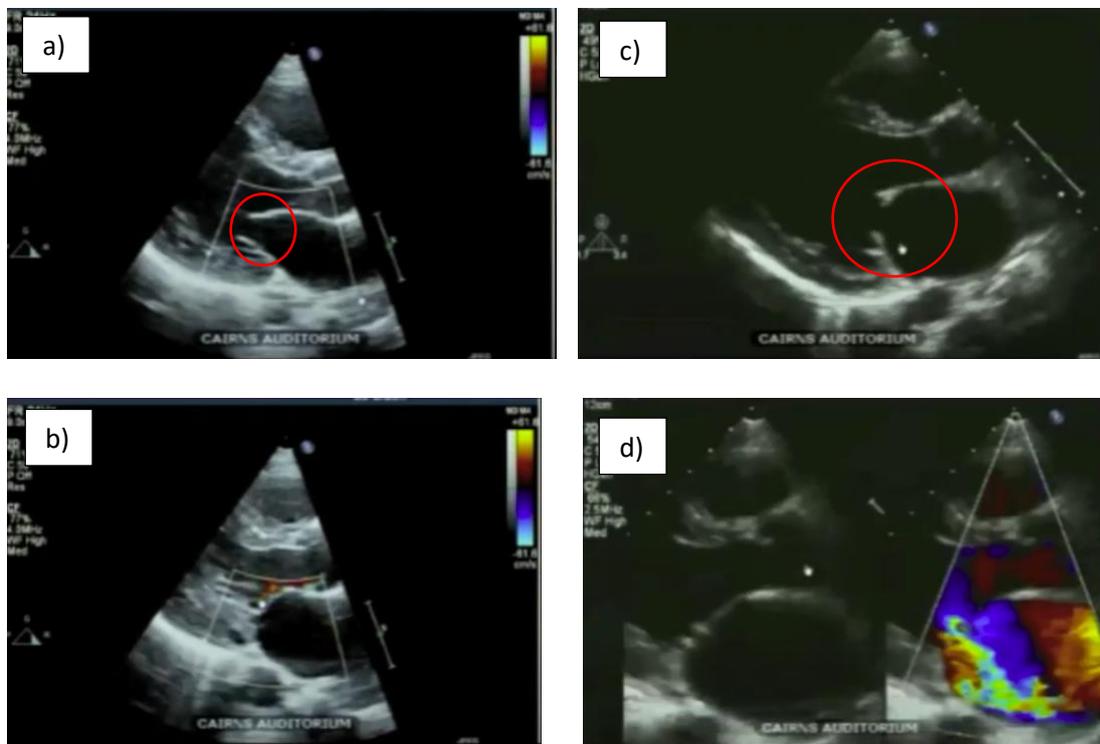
Echocardiogram images collected by echocardiographer Ben Reeves showing patient with healthy heart vs patient with valvular regurgitation due to rheumatic heart disease (RHD). a) Healthy heart with long smooth valve structure upon opening b) Healthy heart with closed mitral valves and minimal regurgitation detectable via Doppler colour imaging c) Definite RHD affected heart with damaged mitral valves upon opening indicated by nodules on ends of valve leaflets d) definite RHD heart with mitral valves closed and high levels of regurgitation detected via Doppler colour imaging. Images available from: <https://www.rhdaustralia.org.au/resources/echocardiography-rheumatic-heart-disease-ben-reeves>
